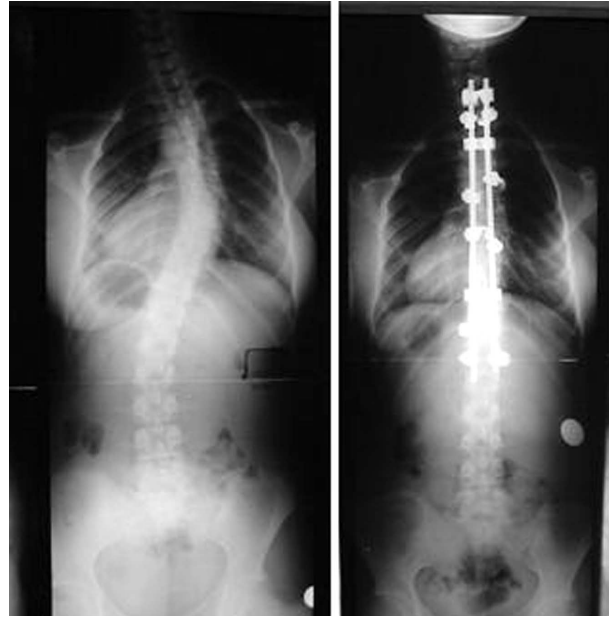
Fourteen year old girl with King Type II curve preoperative (a) and postoperative (b) radiographs were shown. The correction was achieved by derotation maneuver using TSRH system.
